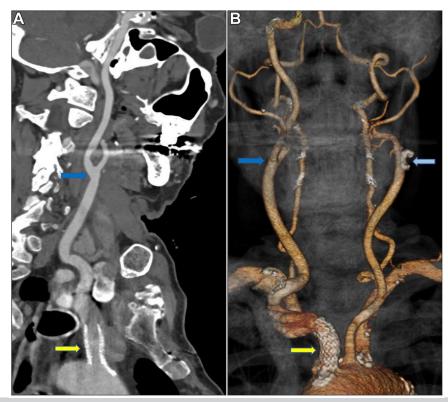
Computed tomography angiogram at 16 months of follow-up showing patency of the innominate artery (IA) stent (*yellow arrow*) and right internal carotid artery (ICA) after endarterectomy (*dark blue arrow*) and a chronically occluded left ICA (*light blue arrow*). A, Sagittal view. B, Three-dimensional reconstruction.
